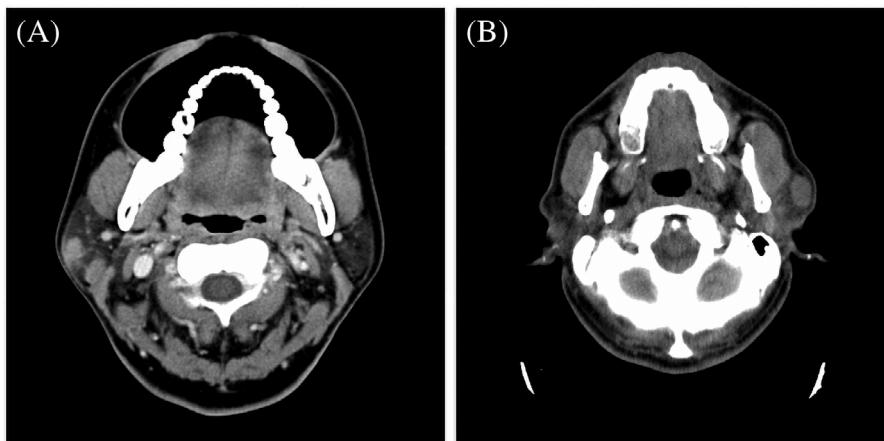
Computed tomography findings. Most lymphoepithelial carcinoma lesions are solitary with a homogenous enhancing pattern.
